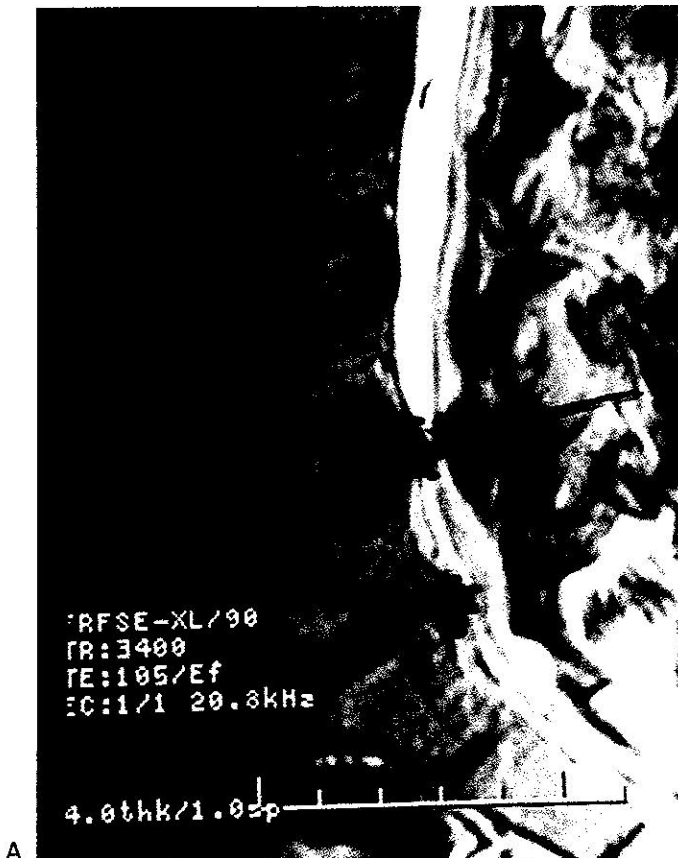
A, Sagittal magnetic resonance imaging (MRI) showing herniated discs at the bottom two lumbar discs, at L4-5 and L5-S1. B, An axial cut of a lumbar spine MRI revealing a left-sided broad-based paracentral disc herniation effacing the thecal sac, causing left-sided lateral recess, foraminal stenosis, and neural compression.
